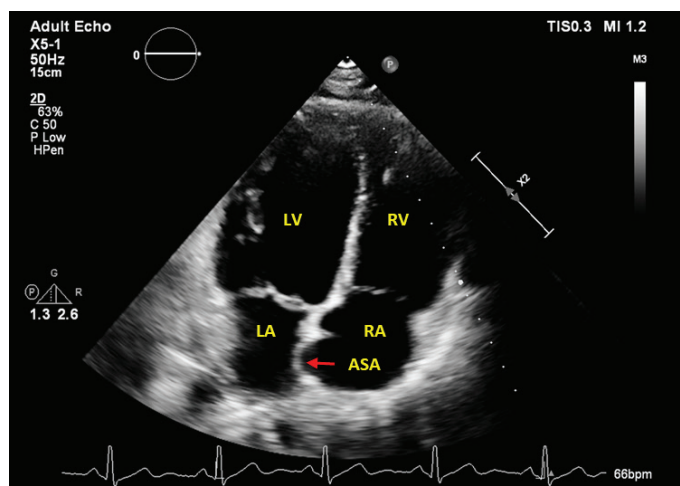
Apical four-chamber view image. The red arrow indicates a type 2 atrial septal aneurysm (ASA) in a study subject. LA, left atrium; RA, right atrium; LV, left ventricle; RV, right ventricle.
